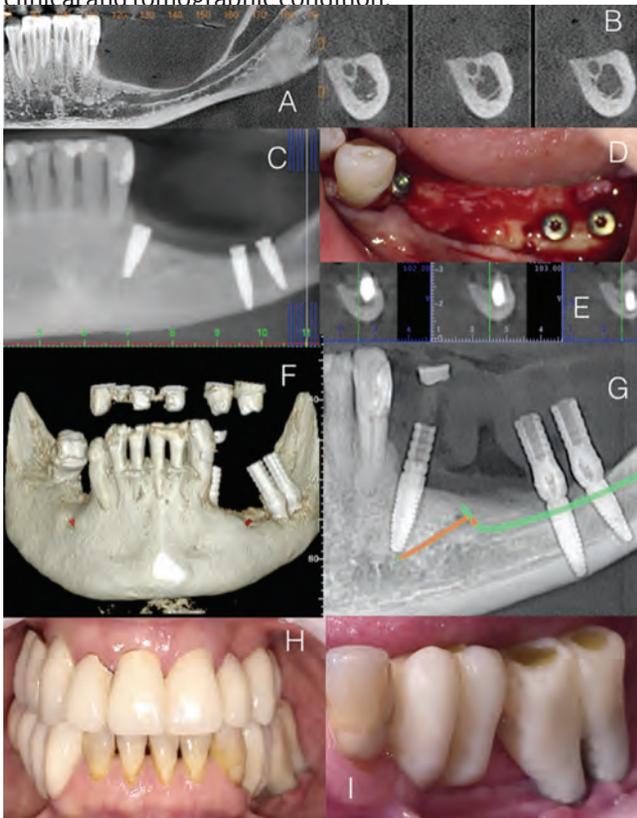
[A] Severe BL in the MPR; [B] The Preoperative CBCT shows no bone above the canal; [C] Implants anchored in the basilar of the mandible; [D] Surgical approach; [E] The Postoperative CBCT shows the implants 18 and 19 passing alongside the nerve; [F] Mandible 3D view of the implants 18 and 19 in the extreme lateral position; [G] Panoramic view of the implants and its titanium provisional abutments; [H] Front and [I] lateral view of FPR.
